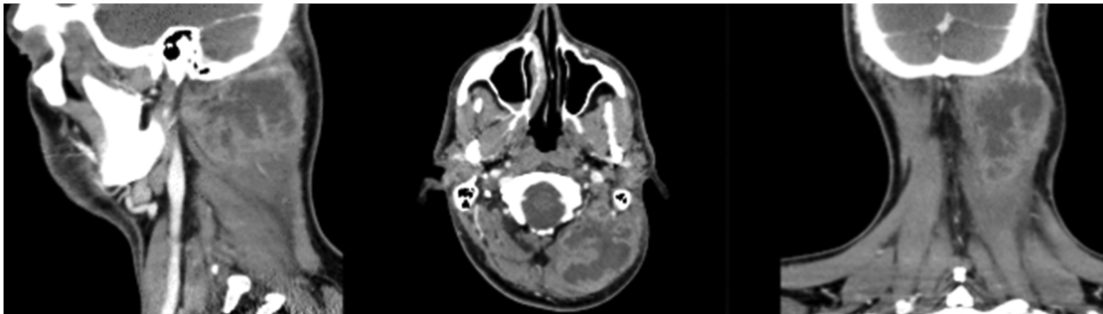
Contrast-enhanced Computed Tomography scan of the neck showing the cervical fluid collection in sagittal, axial and coronal views.
